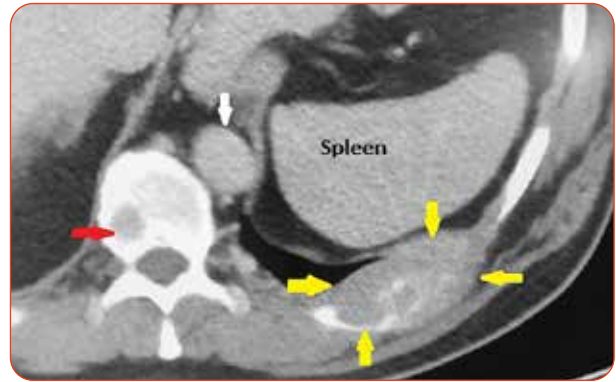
Unenhanced axial CT scan showing left nephrectomy with spleen lying horizontally in renal bed. There is a large destructive lesion involving the left rib with bony destruction and a soft tissue mass (yellow arrows). There is a 2cm mass between the vertebral body and the left hemi-diaphragm in keeping with a secondary deposit (white arrow). There is a lesion in the vertebral body on the right (red arrow).
